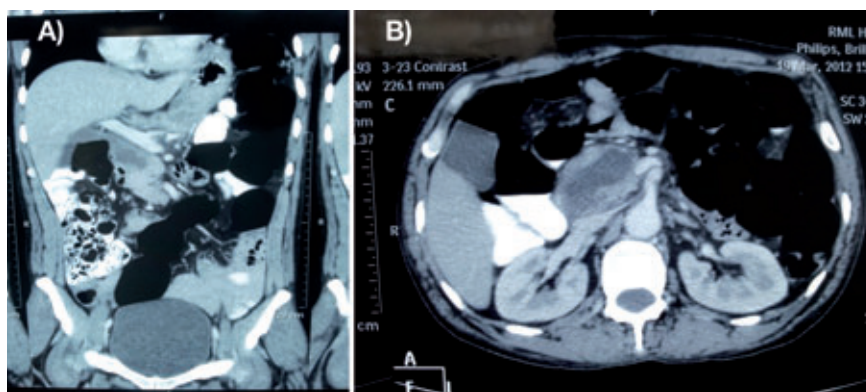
Contrast enhanced computed tomography of abdomen showing aggenesis of dorsal pancreas (A) with intrapancreatic pseudocyst (B).
